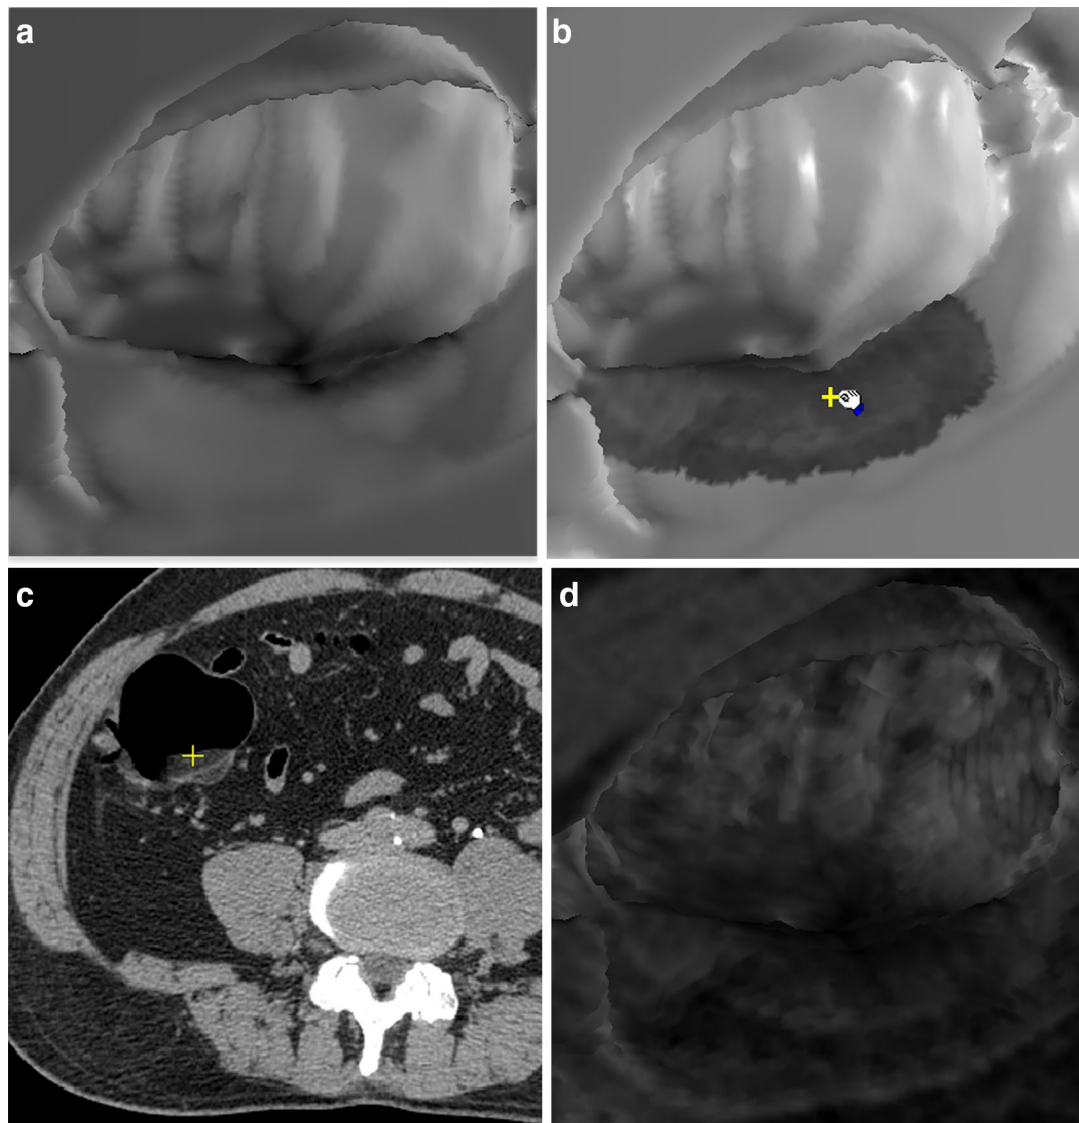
Images of a 62-year-old male. Colonography revealed swelling of the ileocecal valve with narrowing of the terminal ileum in health examination. Comparison of SR, TGM and GM of the lipomatous area on CTC. a SR of a colonic lipomatous tumor. b TGM of the same tumor and a 3D interesting point (cross). c An axial CT image of a correlated colonic lipomatous area (cross). The cross in b shows
